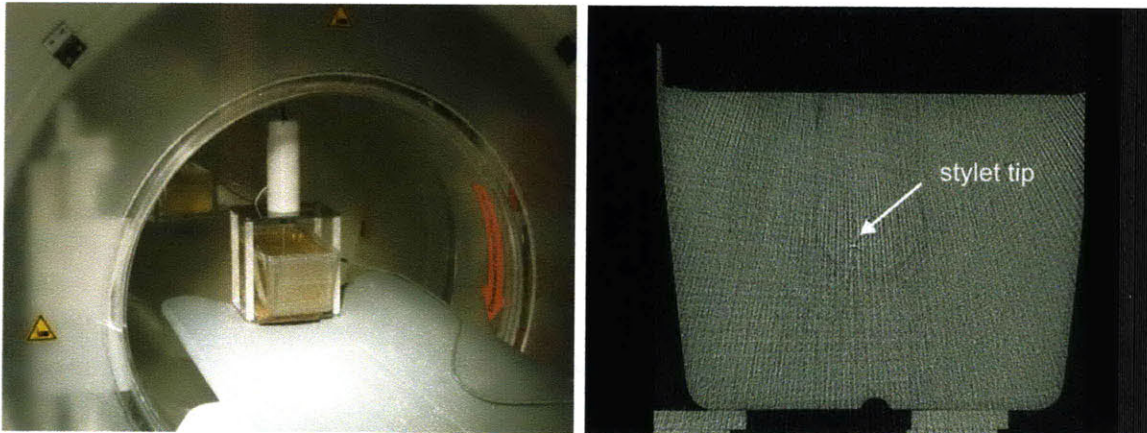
Left, Experimental setup showing the needle steering robot mounted above a container of ballistics gelatin while inside a CT scanner. Right, sample CT scan of the gel with the bright tip of the stylet barely visible.
